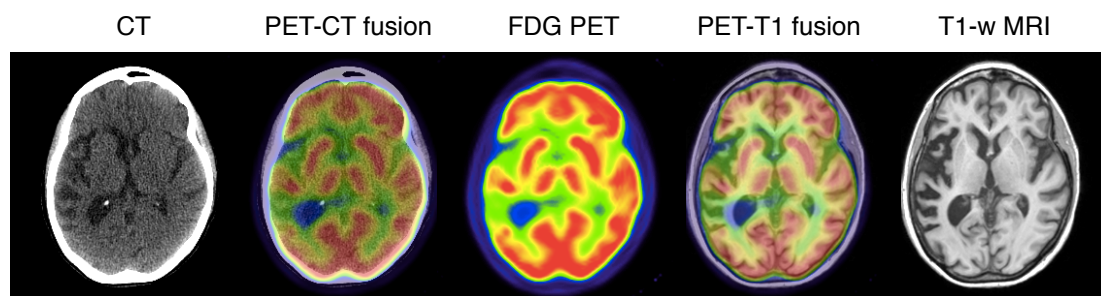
Example of PET, CT, T1-w MR and fused images
